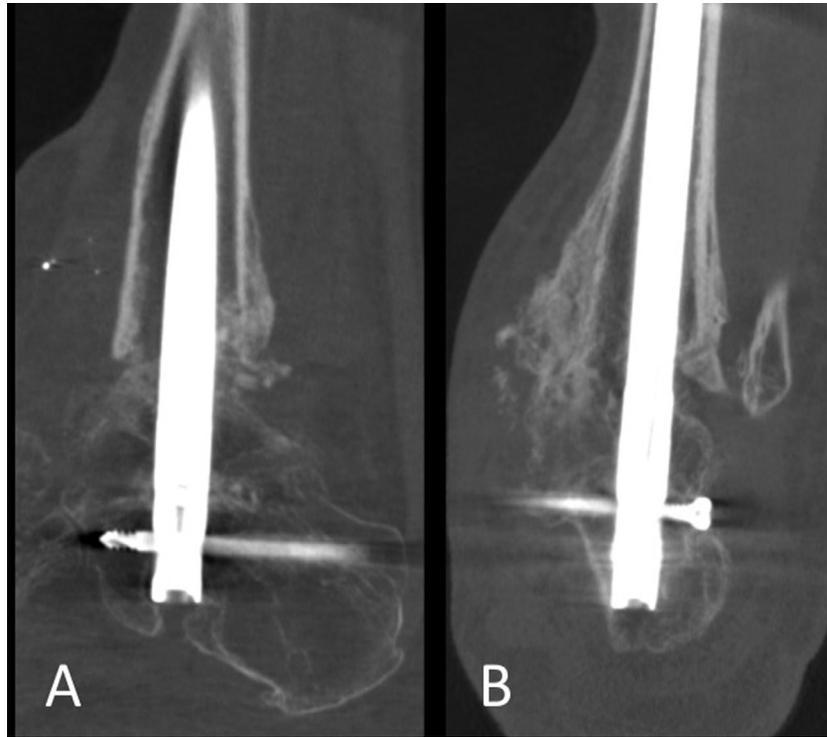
Computed tomographic assessment of union (patient SS). Sagittal (A) and coronal (B) computed tomographic scan cuts 3 months after tibiotalocalcaneal arthrodesis demonstrating >50% bony bridging at the tibiotalar and subtalar arthrodesis sites.
